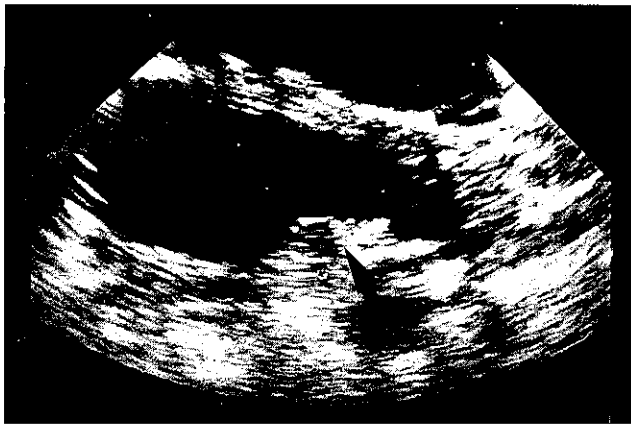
The bladder tumor (↗) was exposed to focused HESW under transabdominal ultrasound guidance.
